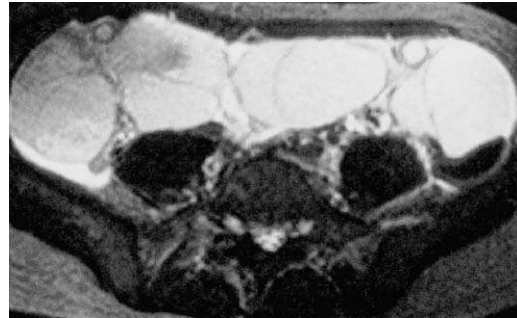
Ovarian hyperstimulation syndrome. T2-weighted image shows a huge mass composed of multiple uniformly sized cysts.
